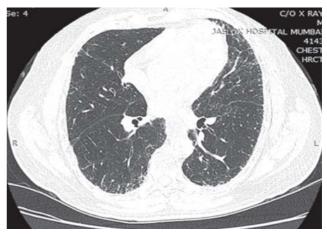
High-resolution computed tomography of thorax (16 months after treatment with diethylcarbamazepine) showing complete resolution of previous ground-glass opacity and residual subpleural interlobular and intralobular thickening in bilateral lower lobes.
